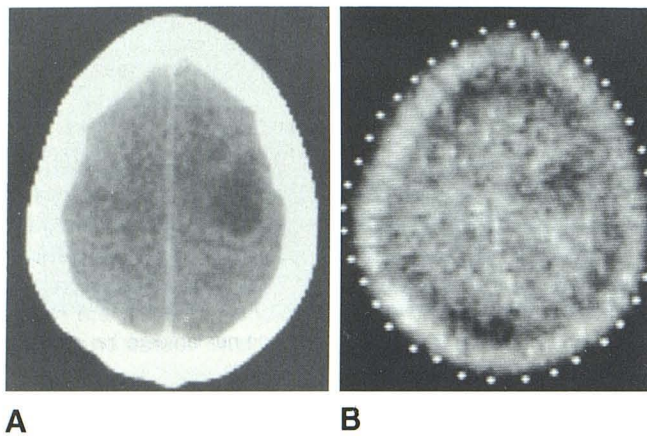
Case 13. Astrocytoma grade I. Low ^{11}C -L-methionine uptake (B) corresponds to hypodense, nonenhancing lesion on CT (A).
